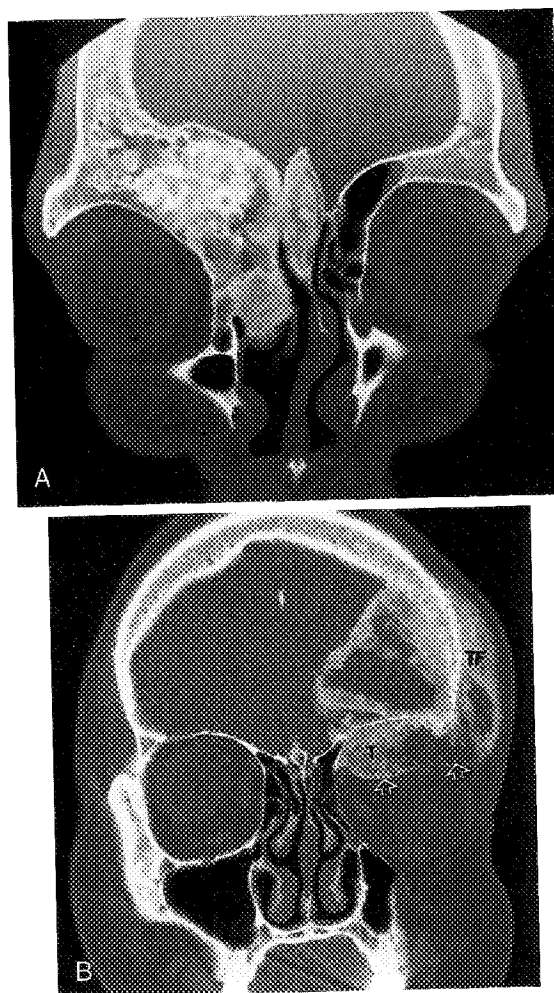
Fibrous dysplasia. A, CT scan shows characteristic changes with bone expansion compatible with fibrous dysplasia. Note lack of periosteal elevation. B, CT scan in a patient with osteogenic sarcoma shows mixed osteoblastic-osteolytic pattern. Note subperiosteal tumor bone formation (T) and displaced periosteum (arrows), which are characteristic of osteochondrogenic sarcomas. Note invasion of temporal fossa (TF) with intratumoral bone formation.
